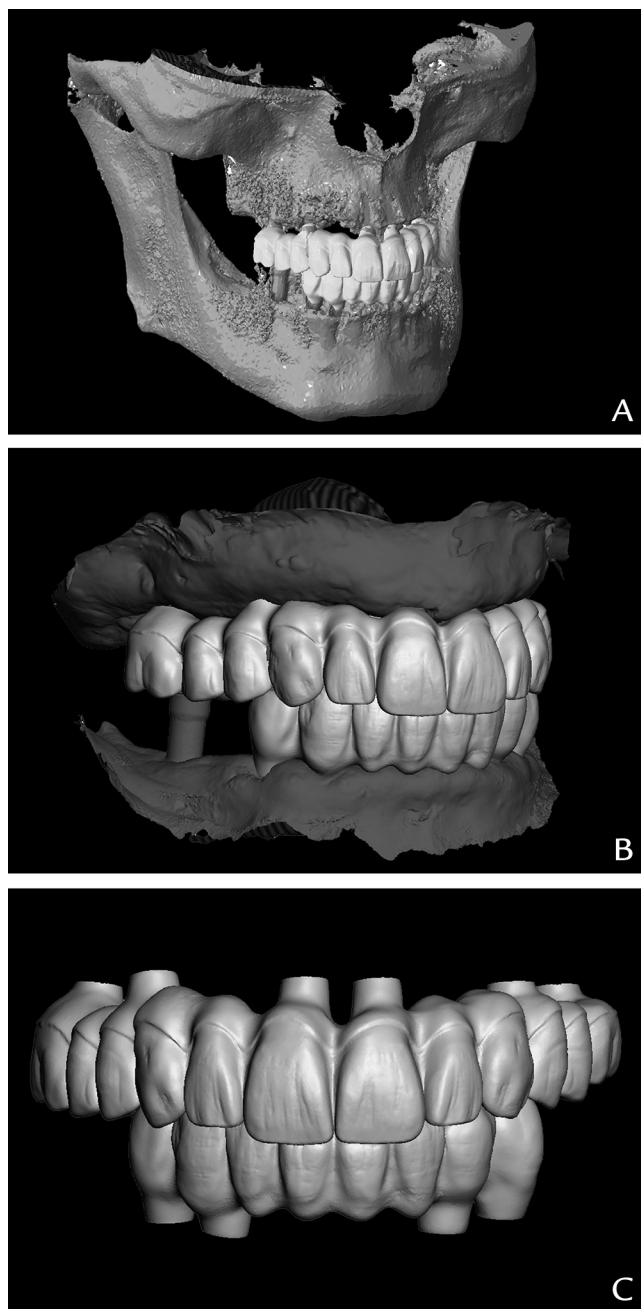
Tooth arrangement design adaptation. A, Tooth arrangement design adapted to STLCBCT3. B, Tooth arrangement design adapted to STLCORR. C, Definitive tooth arrangement design. STL, standard tessellation language.
